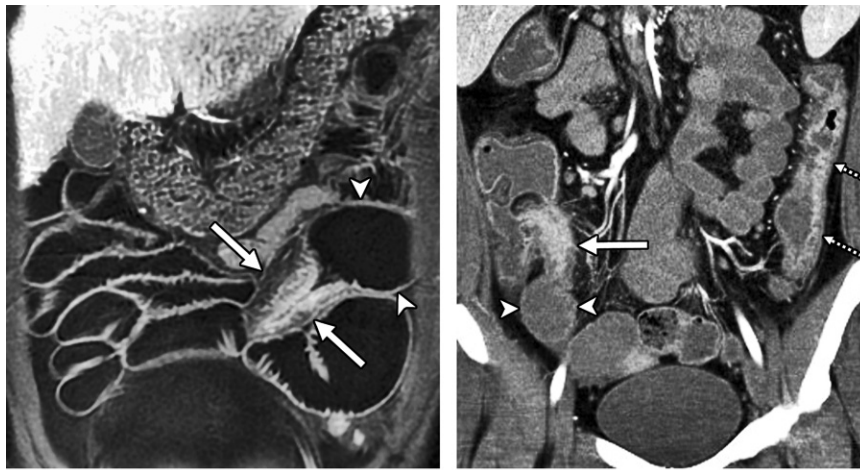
Stricture with imaging findings of active inflammation in two patients with Crohn disease. (a) Coronal contrast-enhanced fat-suppressed T1-weighted MR enterographic image with biphasic oral contrast material shows a segment of ileum with moderate wall thickening, stratified mural hyperenhancement, and luminal narrowing (arrows) associated with moderate to severe upstream small bowel dilation of 5 cm (arrowheads), consistent with a stricture with active inflammation. (b) Coronal contrast-enhanced CT enterographic image with neutral oral contrast material shows moderate wall thickening, stratified mural hyperenhancement, and luminal narrowing in the terminal ileum (solid arrow) with mild upstream small bowel dilation (arrowheads), findings consistent with a stricture with active inflammation. There is also active inflammation in the descending colon (dashed arrows).
